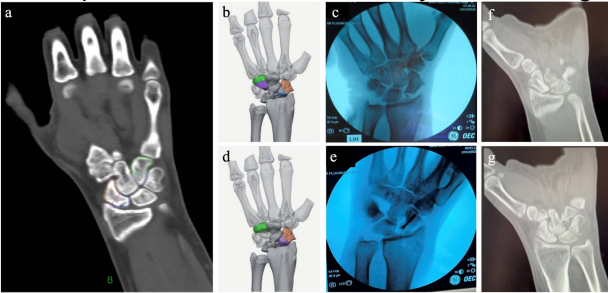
(a) Preoperative CT of patient's wrist used to create the 3D model in Materialise Mimics. (b) 3D render of preoperative wrist showing scaphoid (orange), templated scaphoid to be excised (blue), hamate (green), and templated hemi-hamate autograft (purple). (c) Preoperative X-ray showing the fractured scaphoid proximal pole. (d) Postoperative 3D render showing preserved scaphoid distal pole (orange), hemi-hamate autograft proximal pole (purple), and remaining hamate distal pole (green). (e) Postoperative X-ray showing hemi-hamate autograft fixation with a cannulated 18 mm x 2.2 mm headless compression screw. (f) 2-month follow-up CT showing accuracy of autograft alignment and fixation. (g) 2-month follow-up CT view in plane dorsal to (f), showing autograft alignment and healing around nail.
